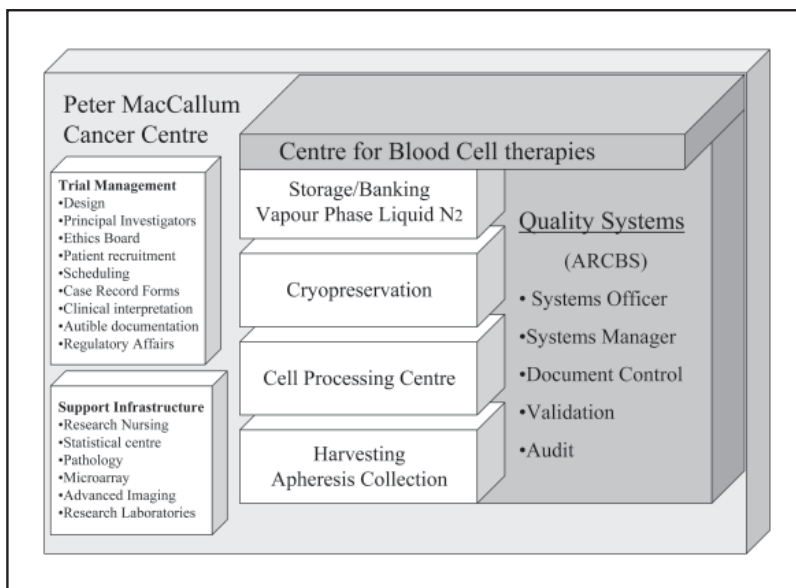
Model of the Centre for Blood Cell Therapies (CBCT) within an academic centre – the Peter MacCallum Cancer Centre. The CBCT is licensed in all aspects of cell procurement, processing, and storage. The quality systems are overseen through collaboration with the Australian Red Cross Blood Service (ARCBS). The CBCT links closely with trial management facilities and the hospital's support infrastructure.
